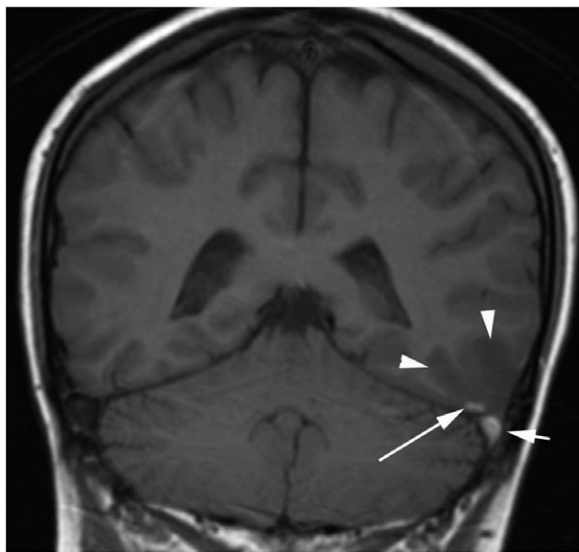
Coronal T1-weighted MRI (TR 472, TE 9.7 ms) showing thrombus within the left transverse sinus (short arrow) and a temporal lobe cortical vein (long arrow), with swelling of the left temporal lobe (arrowheads), consistent with an infarct.
